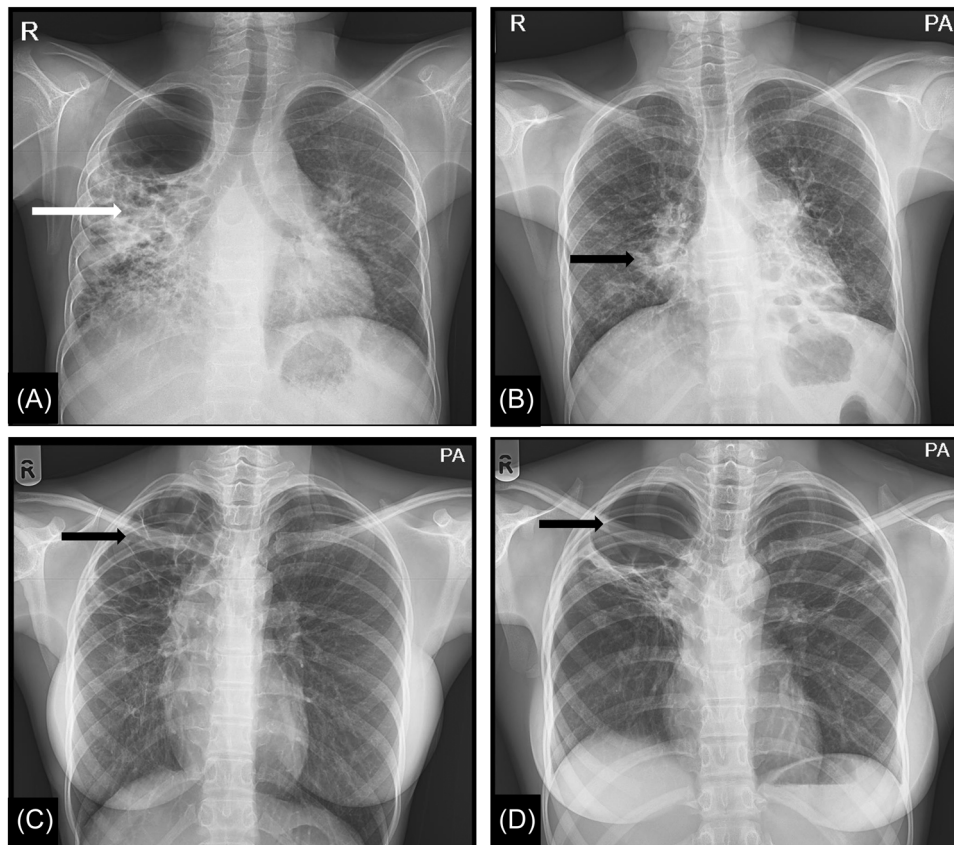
Chest X-ray imaging from participants with severe radiological abnormalities. (A) Bronchiectasis (arrow) with volume loss on the right. (B) Fibrosis (arrow). (C) Fibrosis with bronchiectasis (arrow) in the right upper zone. (D) Fibrosis with volume loss and cavitation (arrow) in the right upper zone.
